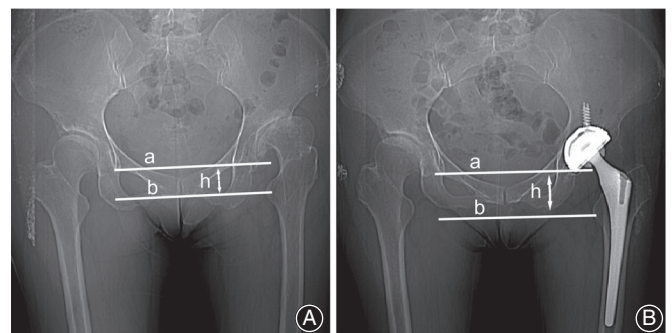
The amount of leg lengthening was measured as the change in the vertical distance (h). A, The vertical distance (h) between the line joining the tear drops (a) and the most medial tip of the lesser trochanter (b) was measured on preoperative computed tomography (CT) scans. B, The vertical distance (h) between the line joining the tear drops (a) and the most medial tip of the lesser trochanter (b) was measured on postoperative CT scans.
